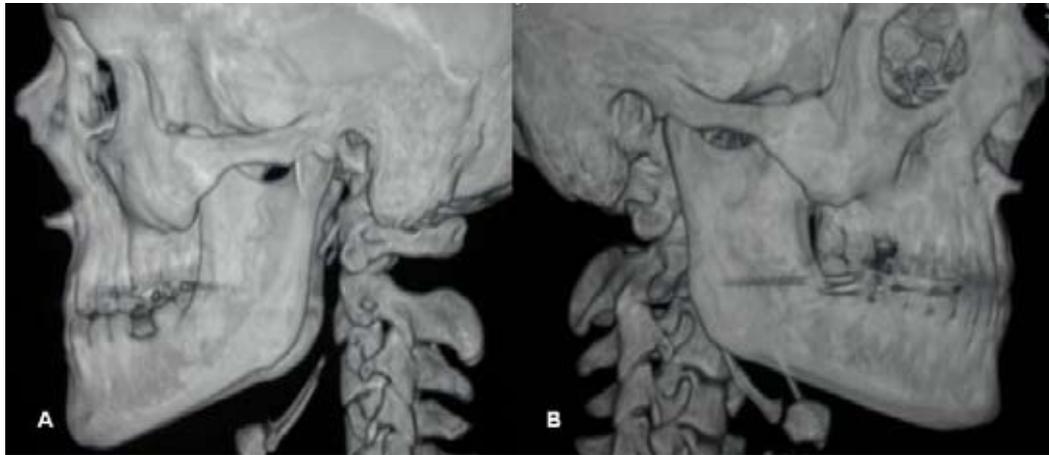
A and B) 3D-CT image of left and right coronoid process hyperplasia.
